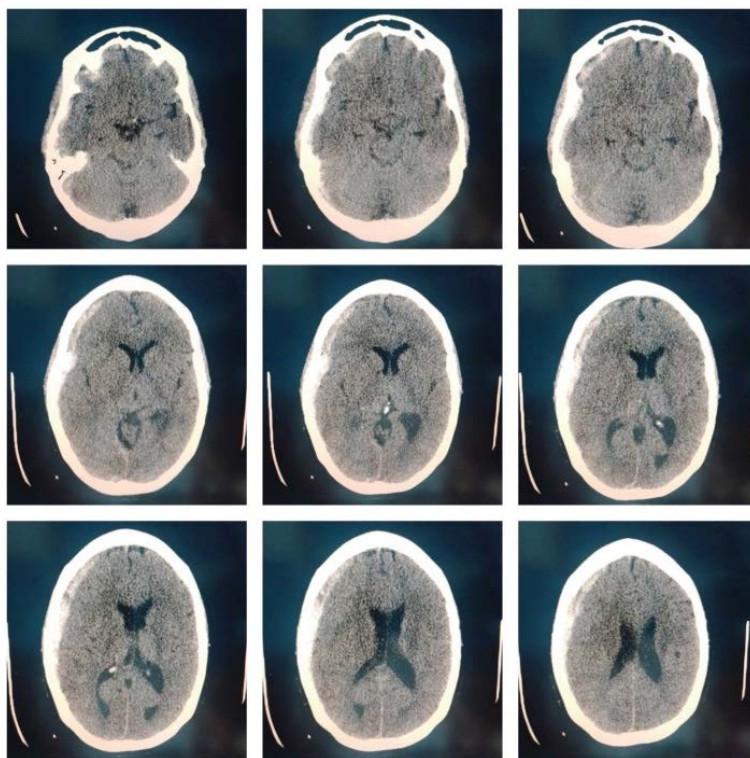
A preoperative computed tomography of the skull of a 38-year-old patient is shown with an image of acute right front temporoparietal subdural hematoma.
